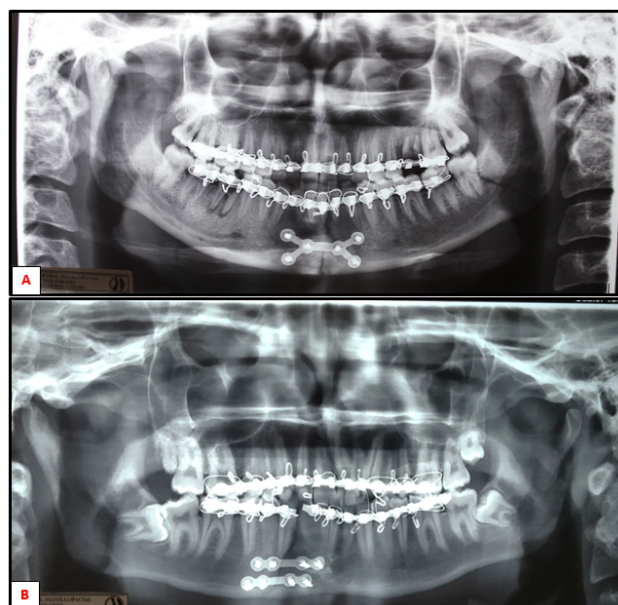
A): Immediate postoperative Digital Orthopantomogram radiograph showing reduction and fixation of symphysis fracture with titanium 2mm double 'Y' shaped mini plate; B): Immediate postoperative Digital Orthopantomogram radiograph showing reduction and fixation of symphysis fracture with titanium 2mm straight 4-hole mini plates
